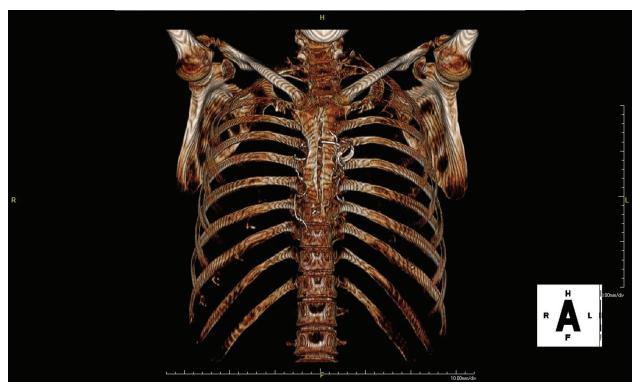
Three-dimensional computed tomography image showing sternal nonunion.
